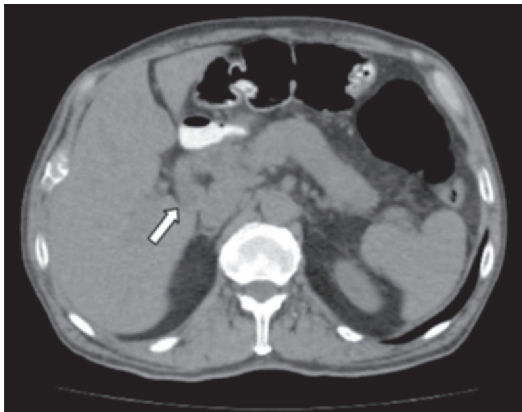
Abdominal computed tomography scan with contrast. Notice mass in the head of the pancreas (arrow).
